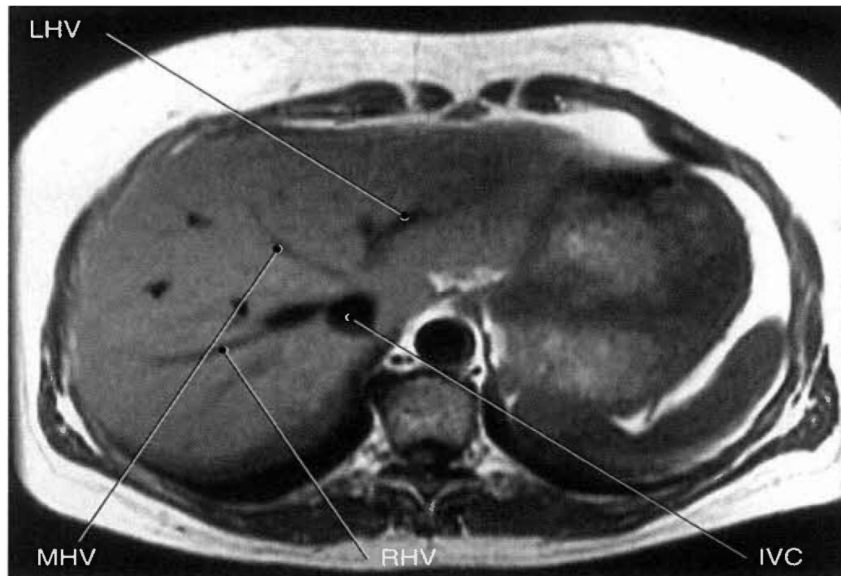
Axial, T1-weighted MR scan of abdomen with hepatic veins(Lorrie, 2007).
